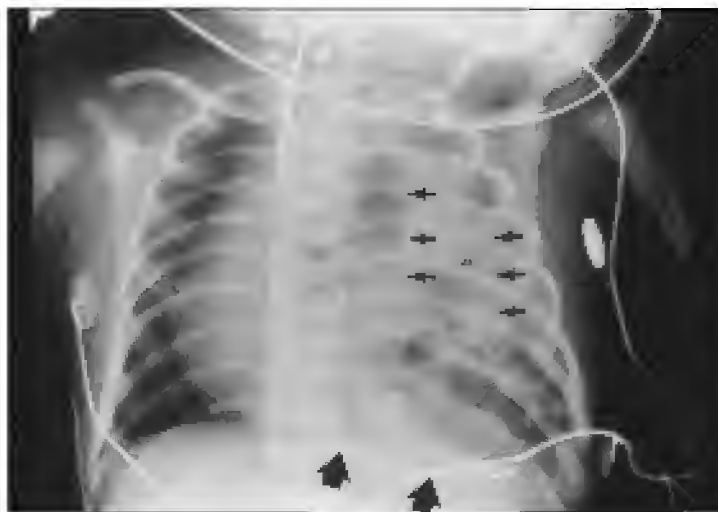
Typical chest x-ray of neonate with left-sided diaphragmatic hernia (Bochdalek type). Small arrows outline loops of bowel within the left chest while large arrows demonstrate nasogastric tube turning back toward the chest. Note also the heart displaced into the right hemithorax.
